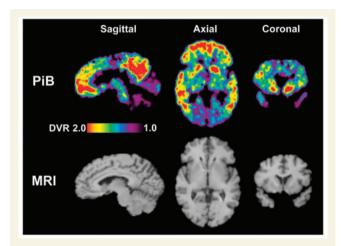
Pittsburgh compound B (PiB) PET and corresponding MRI images from a 52-year-old carrier of a PS2 N141I mutation from the R family with mild Alzheimer's disease (V-34). The Pittsburgh compound B PET images are parametric distribution volume ratio (DVR) images using 90 min of data and the cerebellum as reference as described in Lopresti *et al.* (2005). The MRI is a 1.5 T spoiled gradient recalled downsampled to the PET resolution. Pittsburgh compound B uptake is noted prominently in frontal and parietal cortices and caudate.
